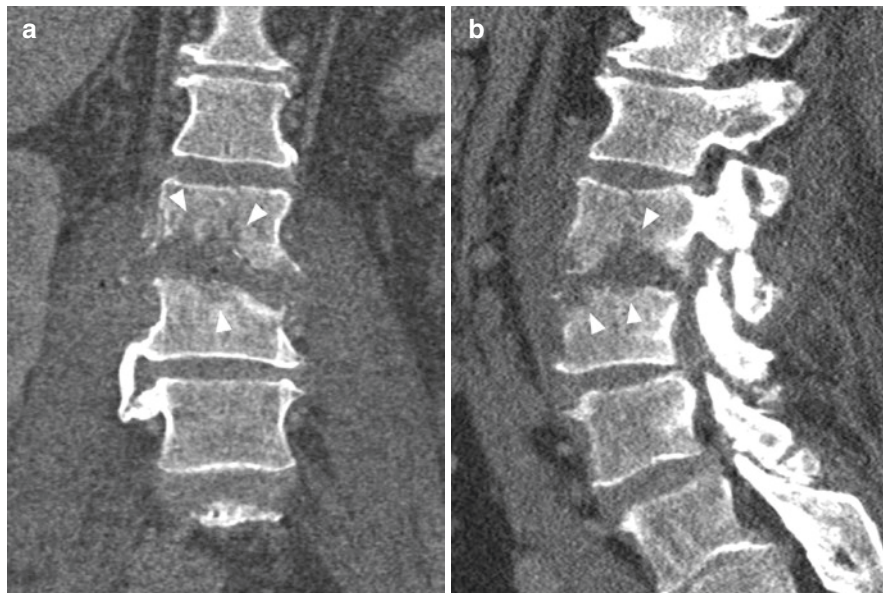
(a) Coronal CT imaging findings of advanced vertebral body destruction due to spondylodiscitis. Arrowheads pointing to extensively eroded vertebral endplates. (b) Sagittal CT imaging findings of advanced vertebral body destruction with fracture of proximal vertebral body (arrowheads)
